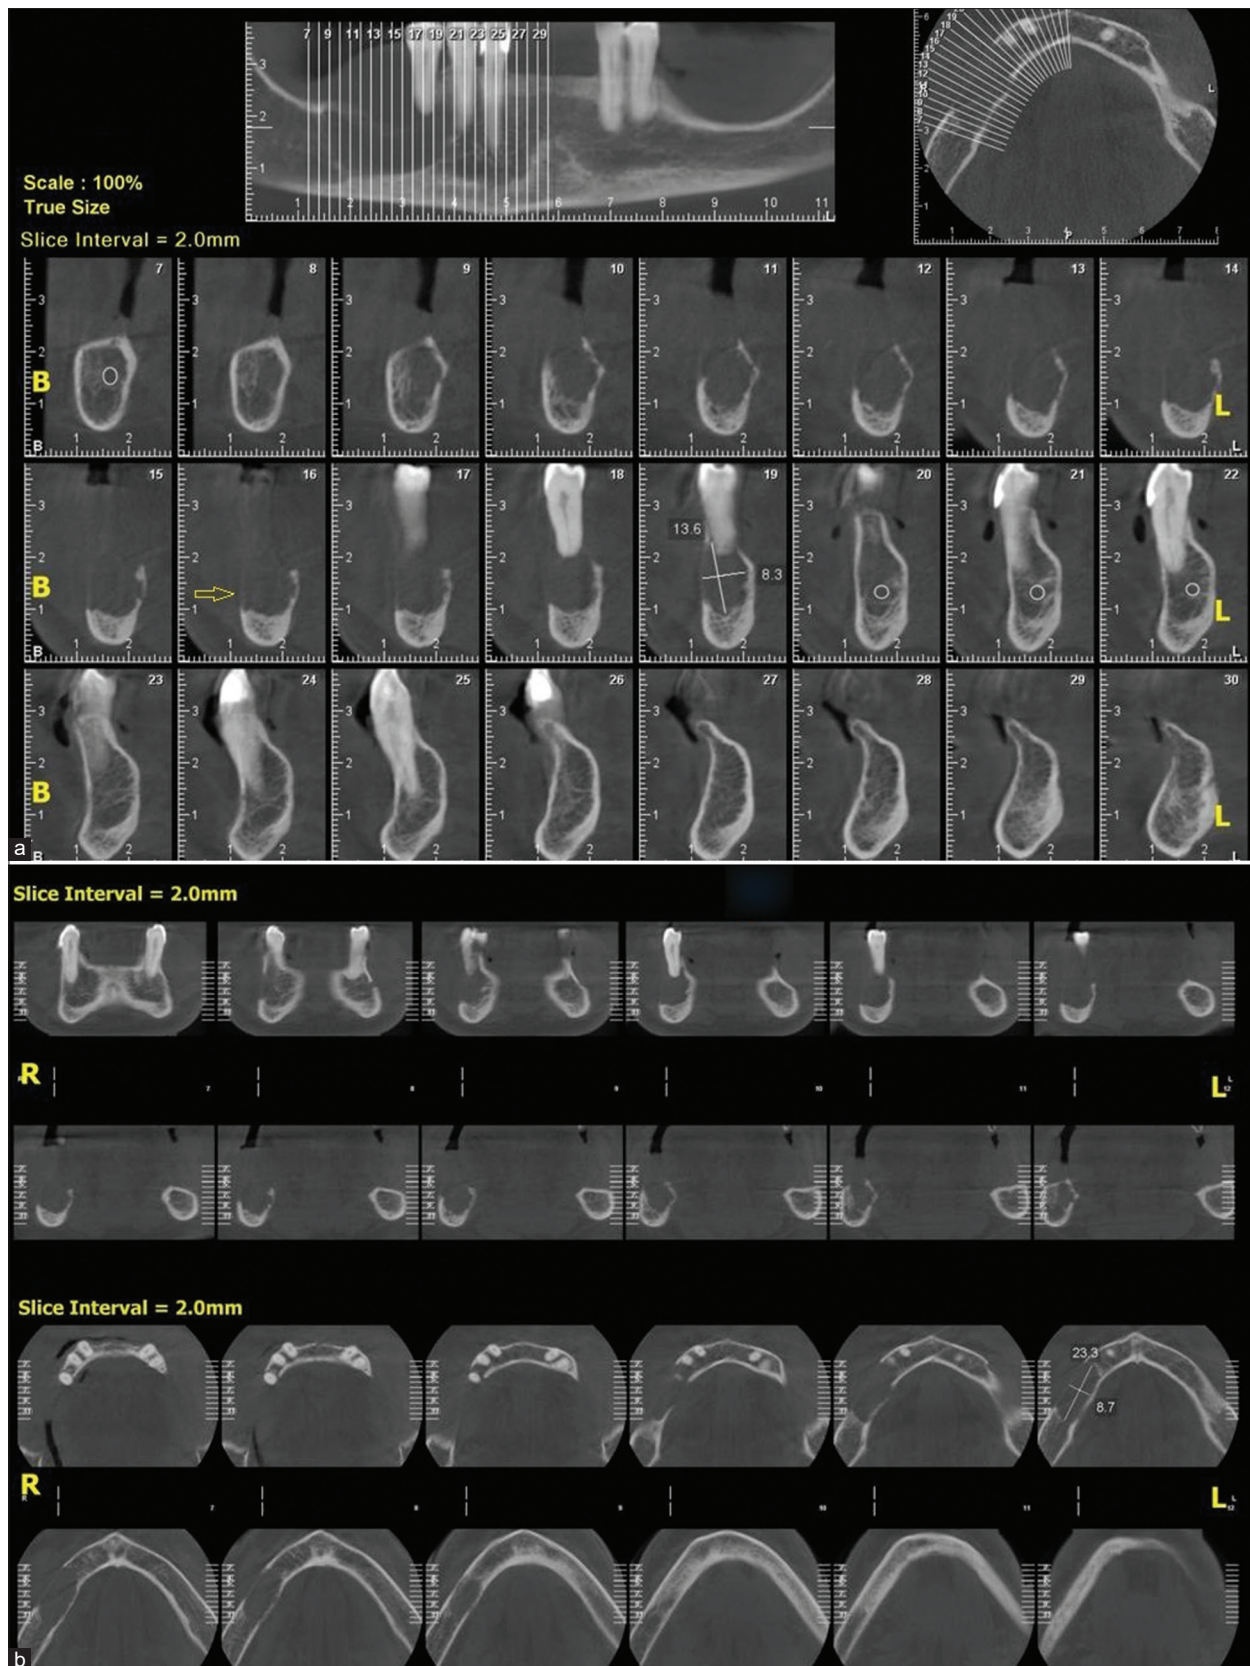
Radiographic findings: (a) There is an ill-defined radiolucent lesion demonstrating perforation of the buccal cortex in some areas (yellow arrow), (b) Coronal and axial view showed extension and lytic structure of the lesion.
